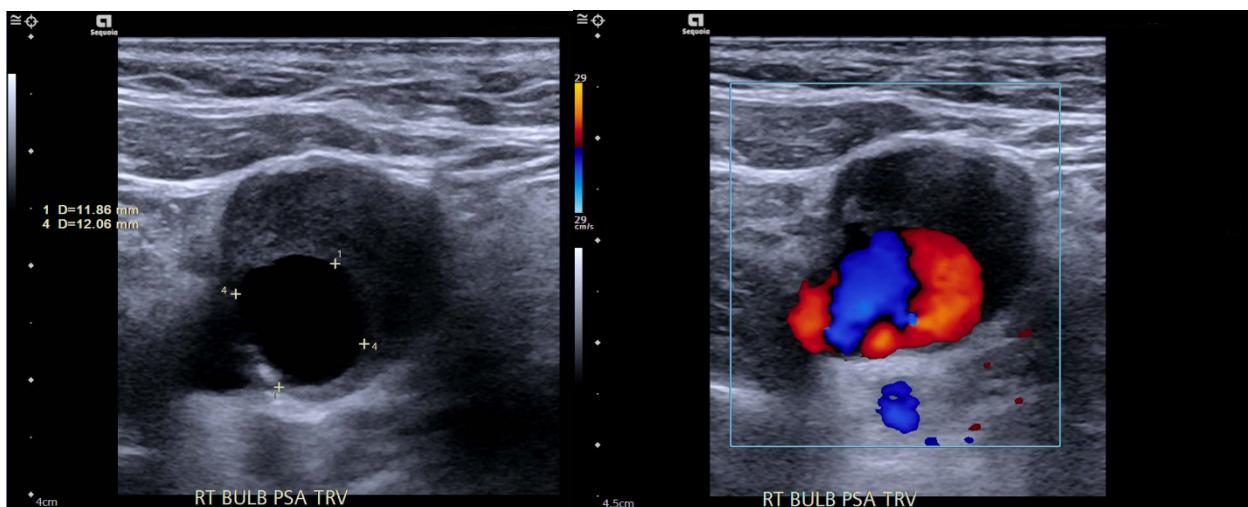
Ultrasound showing pseudoaneurysm formation directly from the patch material. Left – true lumen is measured with yellow crosses. Right – “Pepsi sign” on color Doppler in the context of bidirectional flow from a pseudoaneurysm.
